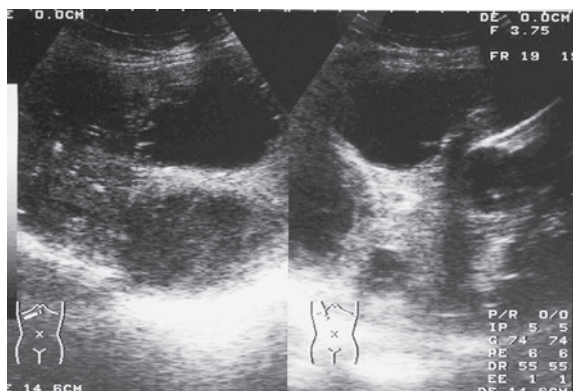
An ultrasonographic image, showing multiple hepatic cysts. One of the cysts in segment 8 had a hypoechoic structure and contained fluid.
